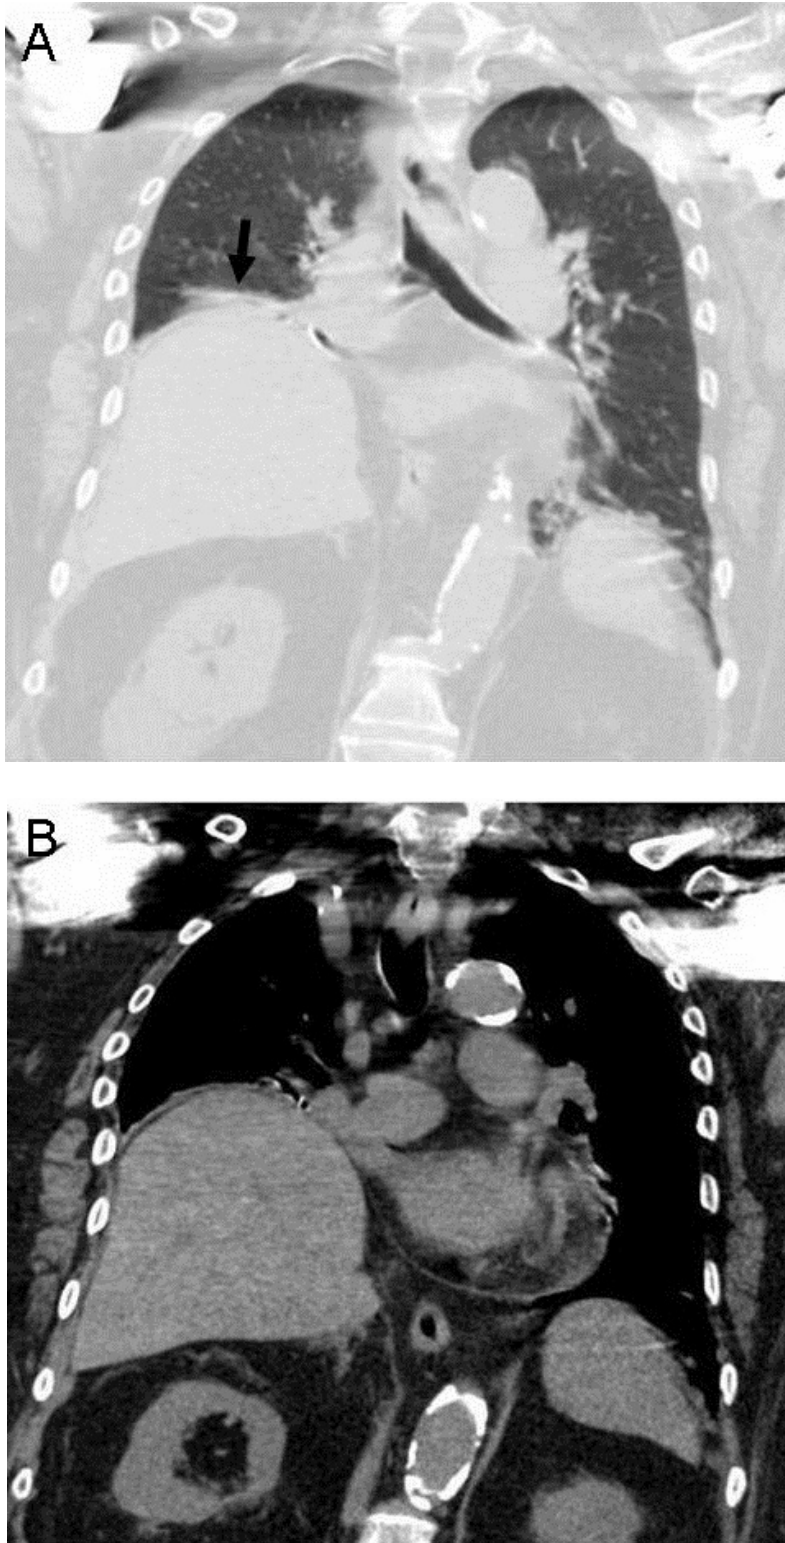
CT scans showing unilateral diaphragm paralysis and atelectasis of right lower lobe (arrow).
